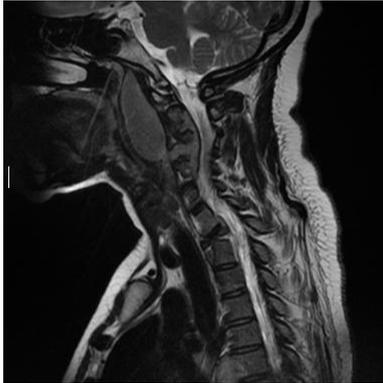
Cervical MRI showing retropharyngeal abscess (C1-C5) extending to the anterior epidural space at C4-C5 and compressing the spinal cord at this level.
